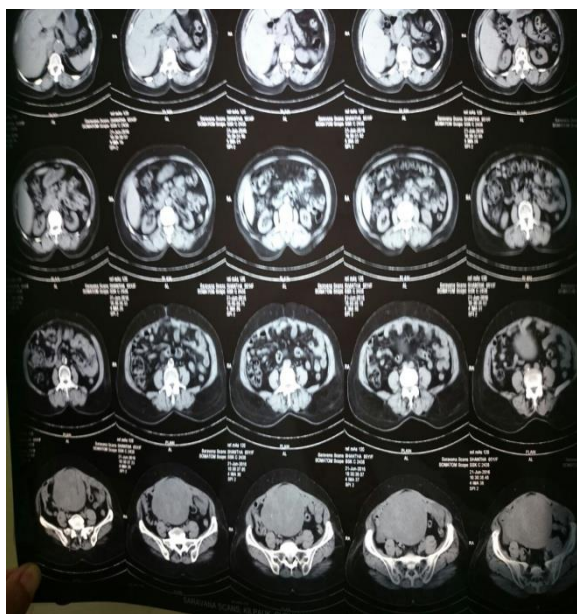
CT abdomen shows pelvic mass anterior to the uterus, cranial to bladder in contact to the broad ligament on the right.
